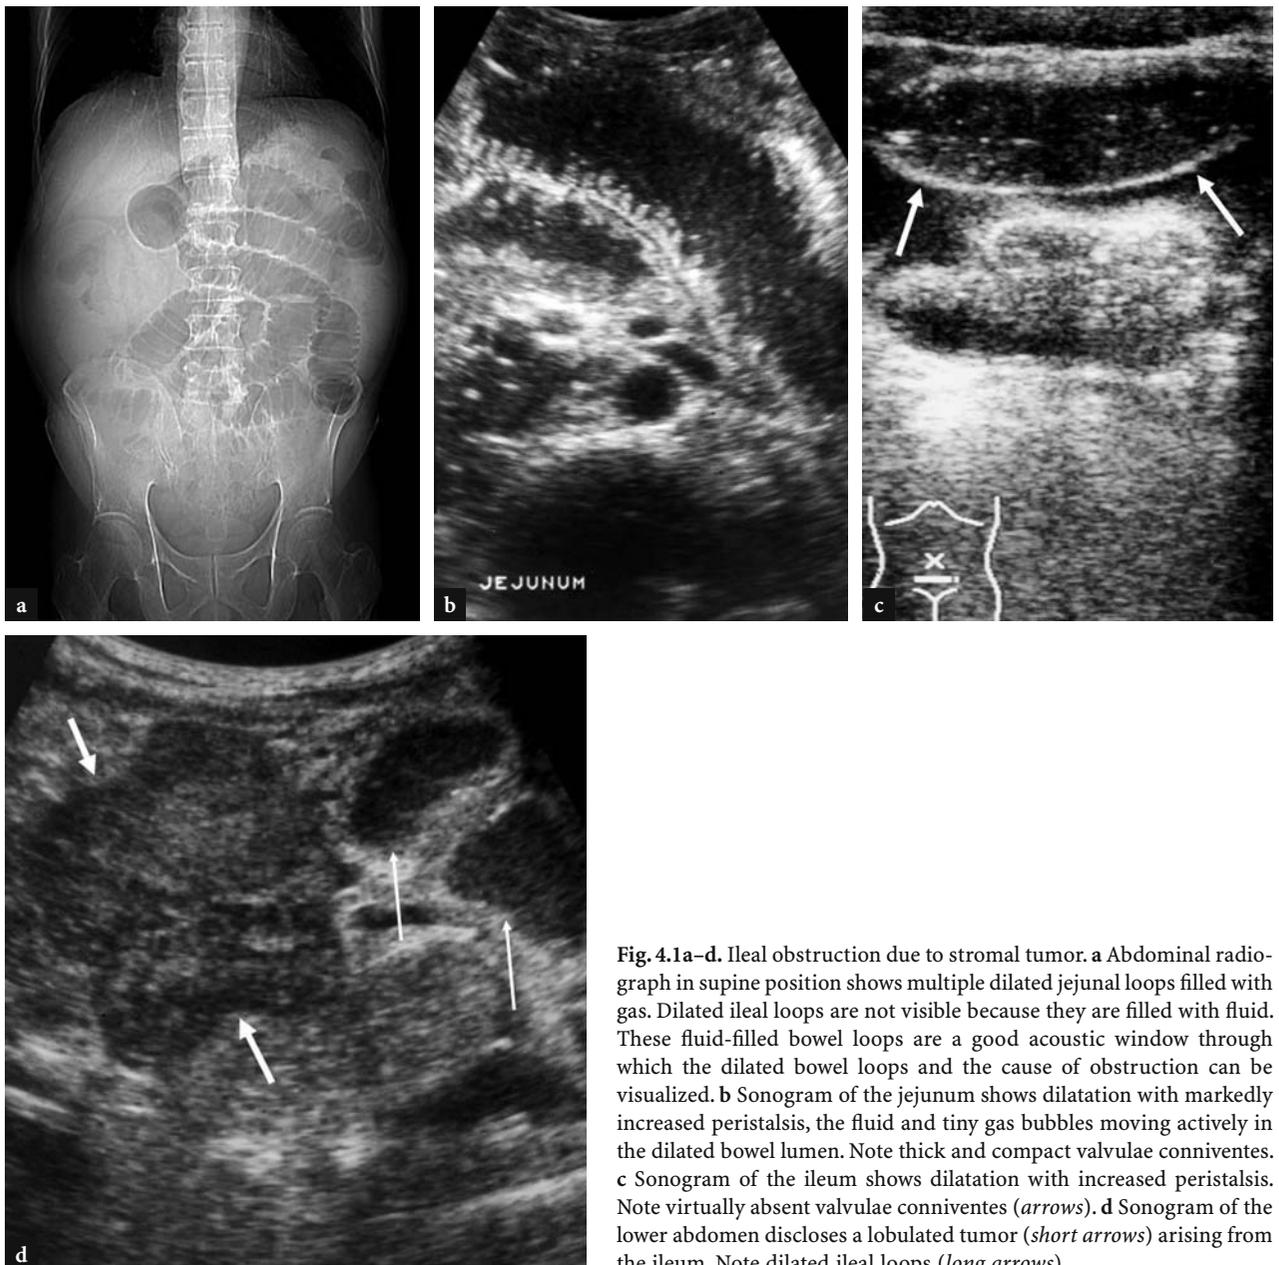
Ileal obstruction due to stromal tumor. a Abdominal radiograph in supine position shows multiple dilated jejunal loops filled with gas. Dilated ileal loops are not visible because they are filled with fluid. These fluid-filled bowel loops are a good acoustic window through which the dilated bowel loops and the cause of obstruction can be visualized. b Sonogram of the jejunum shows dilatation with markedly increased peristalsis, the fluid and tiny gas bubbles moving actively in the dilated bowel lumen. Note thick and compact valvulae conniventes. c Sonogram of the ileum shows dilatation with increased peristalsis. Note virtually absent valvulae conniventes (*arrows*). d Sonogram of the lower abdomen discloses a lobulated tumor (*short arrows*) arising from the ileum. Note dilated ileal loops (*long arrows*)
